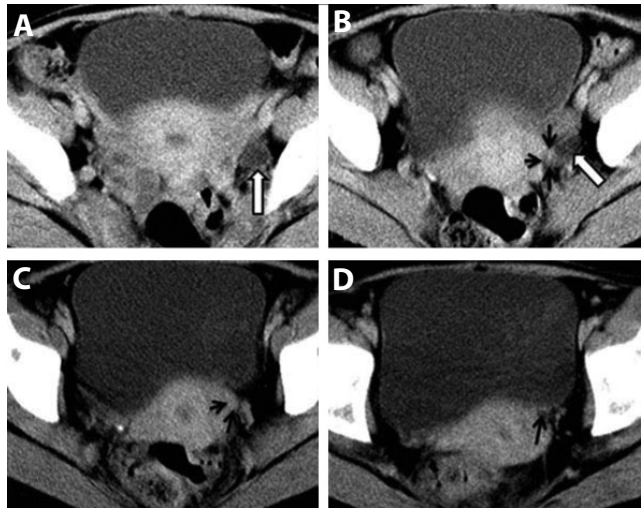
A-D. On axial serial (A-D) CT imaging after contrast media administration, ureteral dilatation (white arrows) and intraureteral enhanced soft tissue mass (black arrows) is clearly seen.
